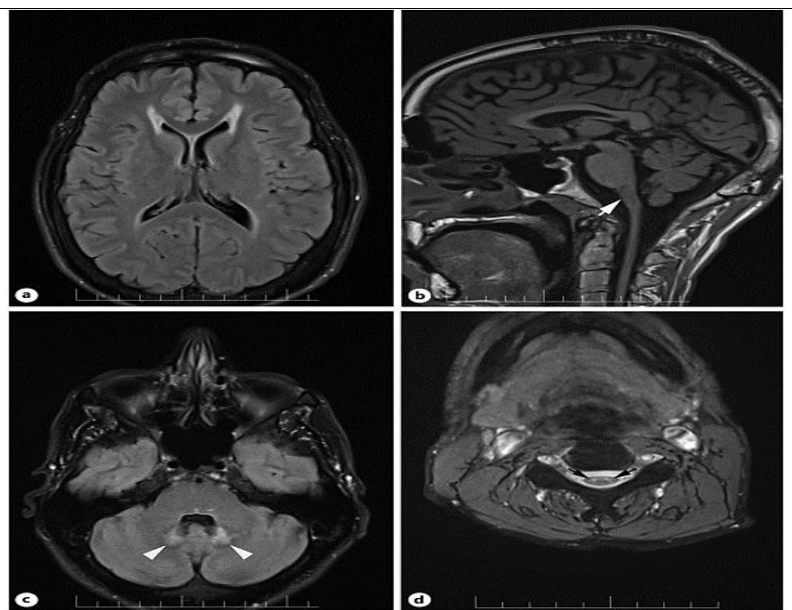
MR imaging of the spinal cord and brain. a) Periventricular hyperintensity in the brain. b) Cerebellar sulci enlargement and atrophy of the medulla oblongata (arrow), maintaining the ventral pons (tadpole sign). c) Dentate nuclei hila hyperintensity (arrowheads). d) Atrophy and hyperintensity of the cervical spinal cord's gray matter.
